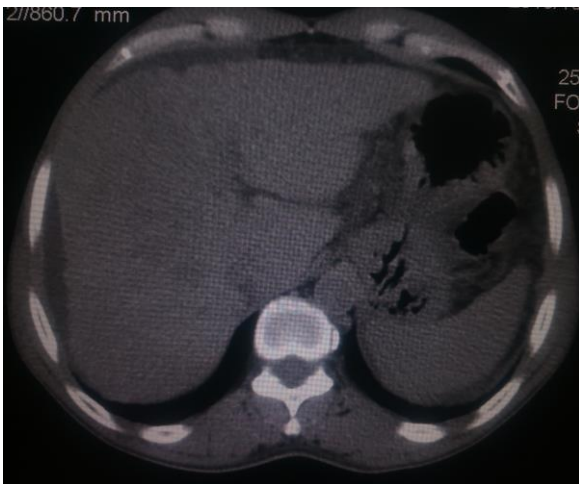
Axial tri-phasic spiral CT images shown HCC with metastases in left kidney.
